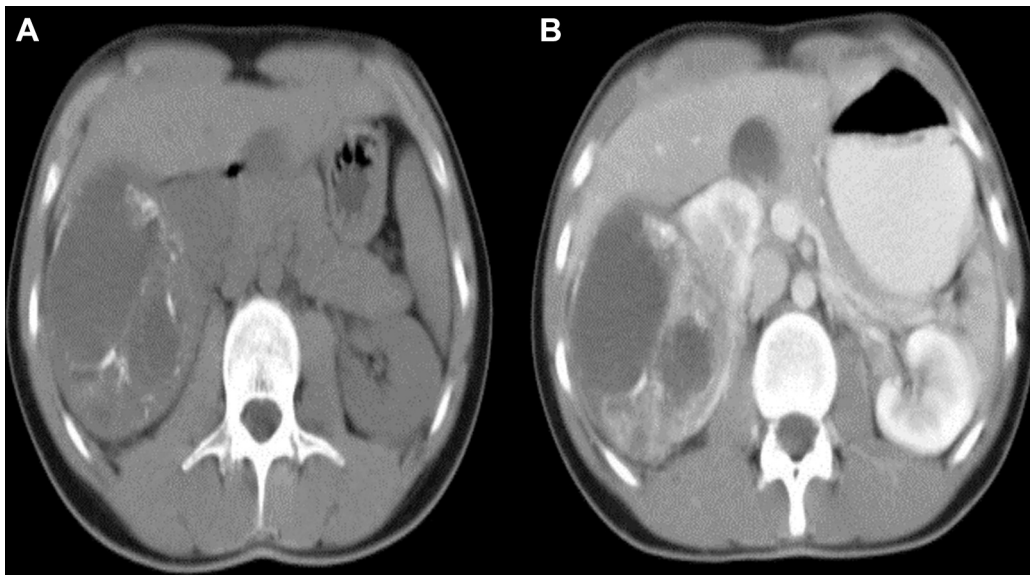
Abdominal CT scan showed: (A) a heterogeneous mass in the mid pole right kidney with some areas of calcification. (B) The mass enhanced after contrast material administration.
